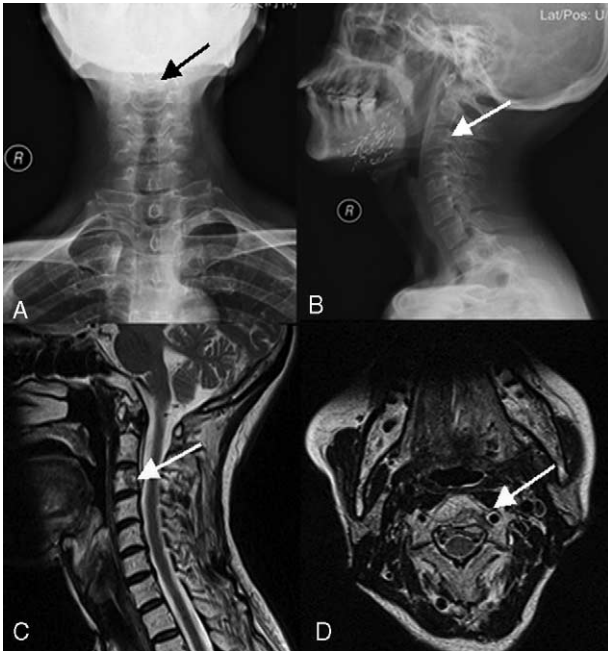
X-ray imaging (A and B) showed that the C3 posterior edge density was slightly decreased (arrow). T1-weighted magnetic resonance images without contrast enhancement (C, sagittal; D, axial) demonstrated a subtle decrease in signal in the C3 vertebral body (arrow).
